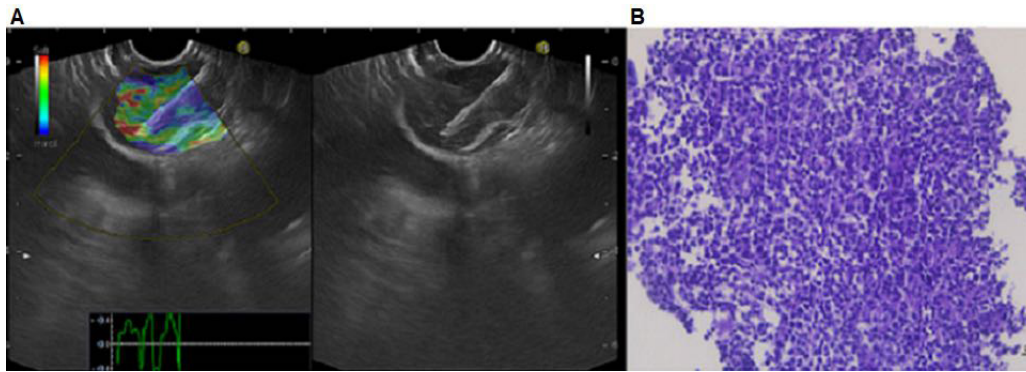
(A) Endoscopic ultrasound with elastography of the hypoechoic lymph node aspiration with 22G needle in correspondence of the paraoesophageal station. The elastography showed a predominantly blue pattern suspected for malignant lymph node. (B) Undifferentiated small round cell neoplasm consisting of relative monomorphic elements cohesive with hyperchromic nuclei and poor eosinophilic cytoplasm (All images are 20× magnification).
